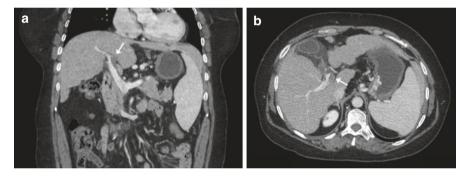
Partial trunk portal vein thrombosis (arrows) documented in a CT-scan. (a) Coronal CT sequence; (b) Axial CT sequence
